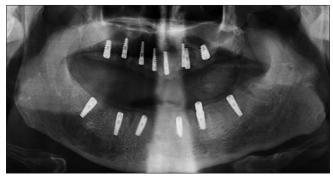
Postimplant placement orthopantomogram
